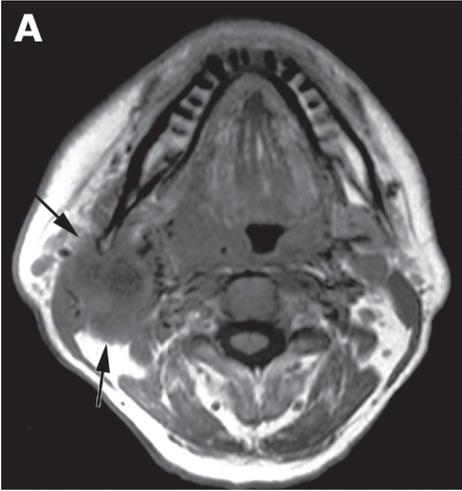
A 63 year-old patient with a T3N2b oropharyngeal carcinoma treated with chemoradiotherapy. Axial T1-weighted spin-echo (700/15) MR image shows a node with capsular contour irregularity and infiltration of adjacent planes, suspicious extranodal spread (arrows) in the right subdigastric area.
